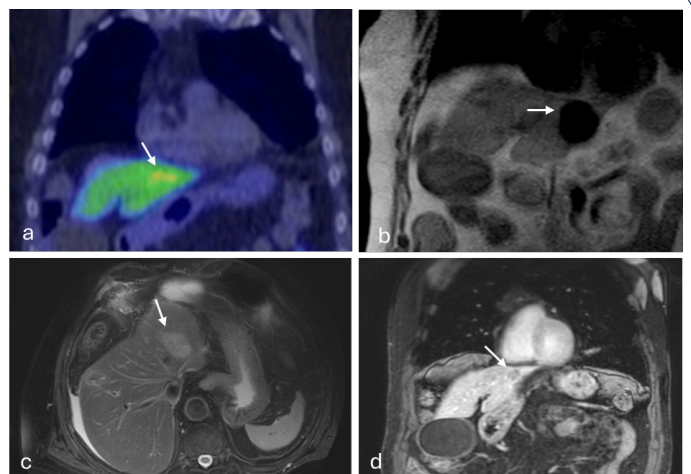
56-year-old male with prostate cancer metastasis in hepatic segment II abutting the diaphragm, 3.2 mm from the cardiac structure. (a) Pre-procedural coronal PET/CT demonstrating FDG-avid activity (arrow) at the hepatic dome immediately inferior to the cardiac border. (b) Pre-procedural coronal contrast-enhanced T1-weighted MRI showing the enhancing lesion (arrow) abutting the diaphragm. (c) Immediate post-ablation coronal T2-weighted MRI demonstrating the hypointense iceball (arrow) at the hepatic dome with preserved T2 signal at the superior margin, confirming absence of myocardial contact. (d) Follow-up coronal PET/CT demonstrating complete metabolic response (arrow) with no in-field local tumor progression.
